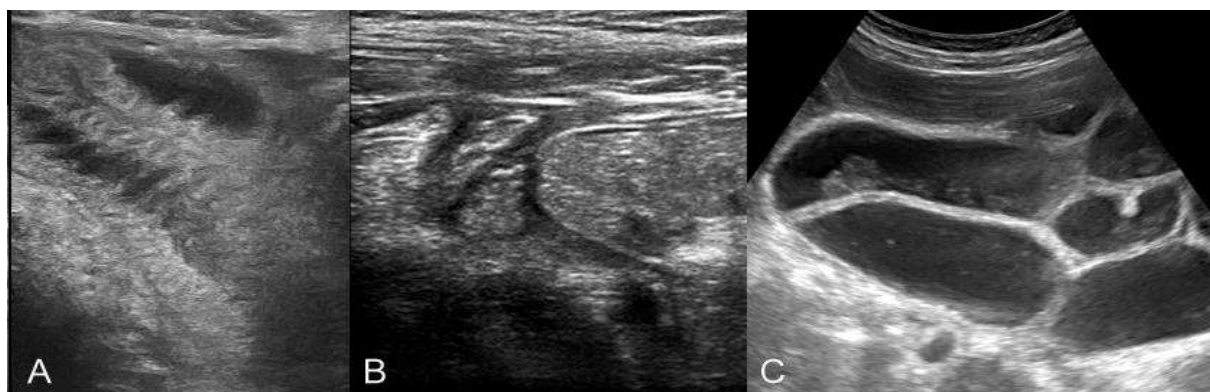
The sonographic sign of bowel obstruction: A) Visibility of valvulae conniventes as a stack of coin. B) Transit point of obstruction as dilatation and collapse of affected loop due to adhesion. C) Fluid-filled and sausage-shaped dilatation of loops.
